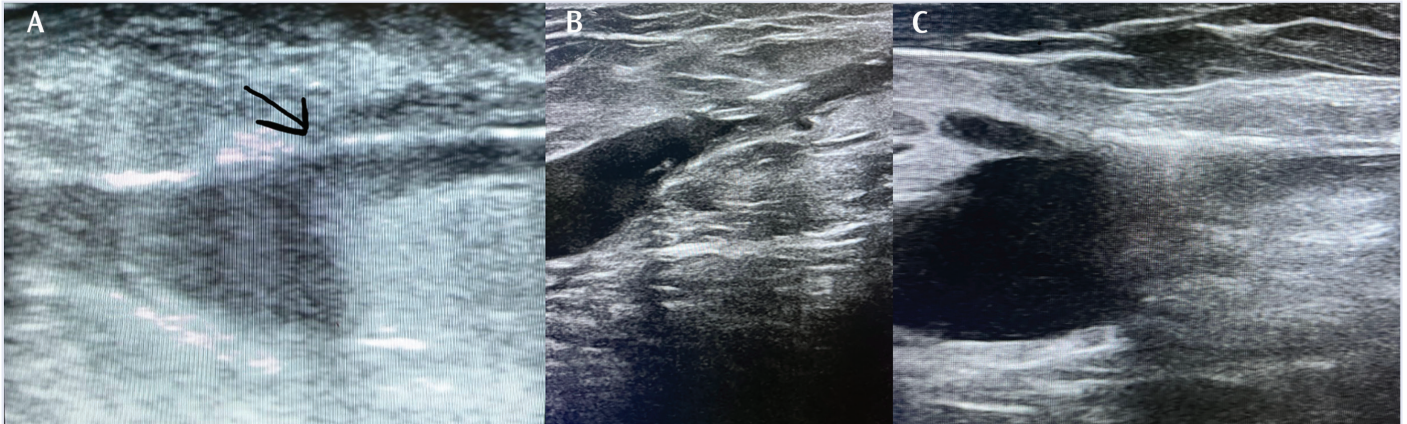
Intraoperative catheter positioning and postoperative saphenofemoral junction imaging. (A) Intraoperative ultrasound image demonstrating proximal positioning of the radiofrequency ablation catheter at the saphenofemoral junction (arrow). (B) Postoperative duplex ultrasonography image of the saphenofemoral junction showing a 0-PD distance of -5 mm, consistent with a flush-free ablation strategy. (C) Postoperative duplex ultrasonography image of the saphenofemoral junction showing a 0-PD distance of -1 mm, consistent with an optimal flush ablation strategy.
